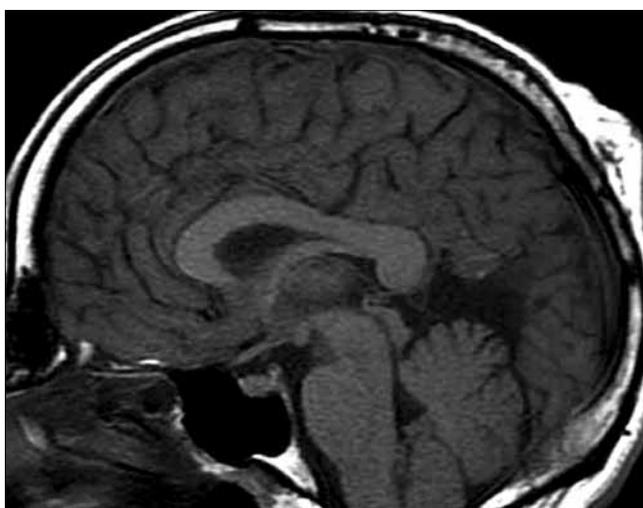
Sagittal T1-weighted magnetic resonance image: An abnormal cerebro-spinal fluid tract between the superior cerebellar cistern and a calvarial defect.
